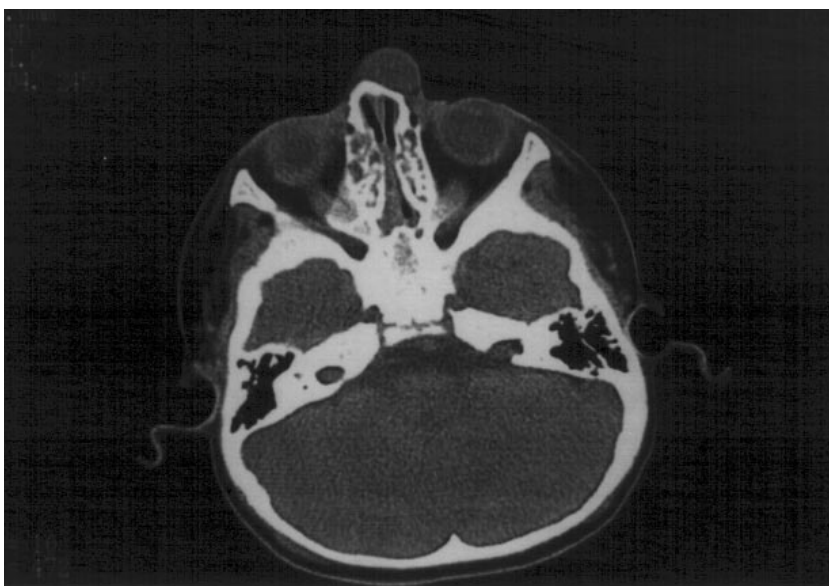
CT scan shows a subcutaneous swelling, 2x1 cm in size, on the left side of the nose, and eroded distal nasal bone on the left.
